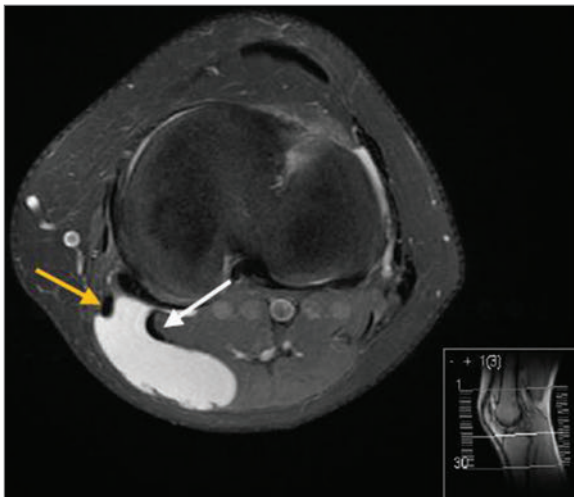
Axial MRI of the same knee demonstrated in ► Fig. 10.61 and ► Fig. 10.62. A high-signal swelling in keeping with a Baker's cyst may be seen to extend posteriorly between the tendons of semimembranosus (yellow arrow) and medial gastrocnemius (white arrow).
